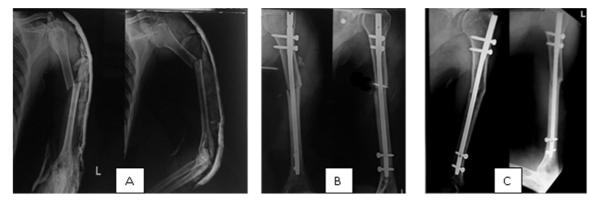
45 year old male with fracture shaft humerus treated with intra-medullary nailing. A: Pre-operative radiograph; B: Immediate post-operative radiograph; C: Radiograph on 1 year follow-up
